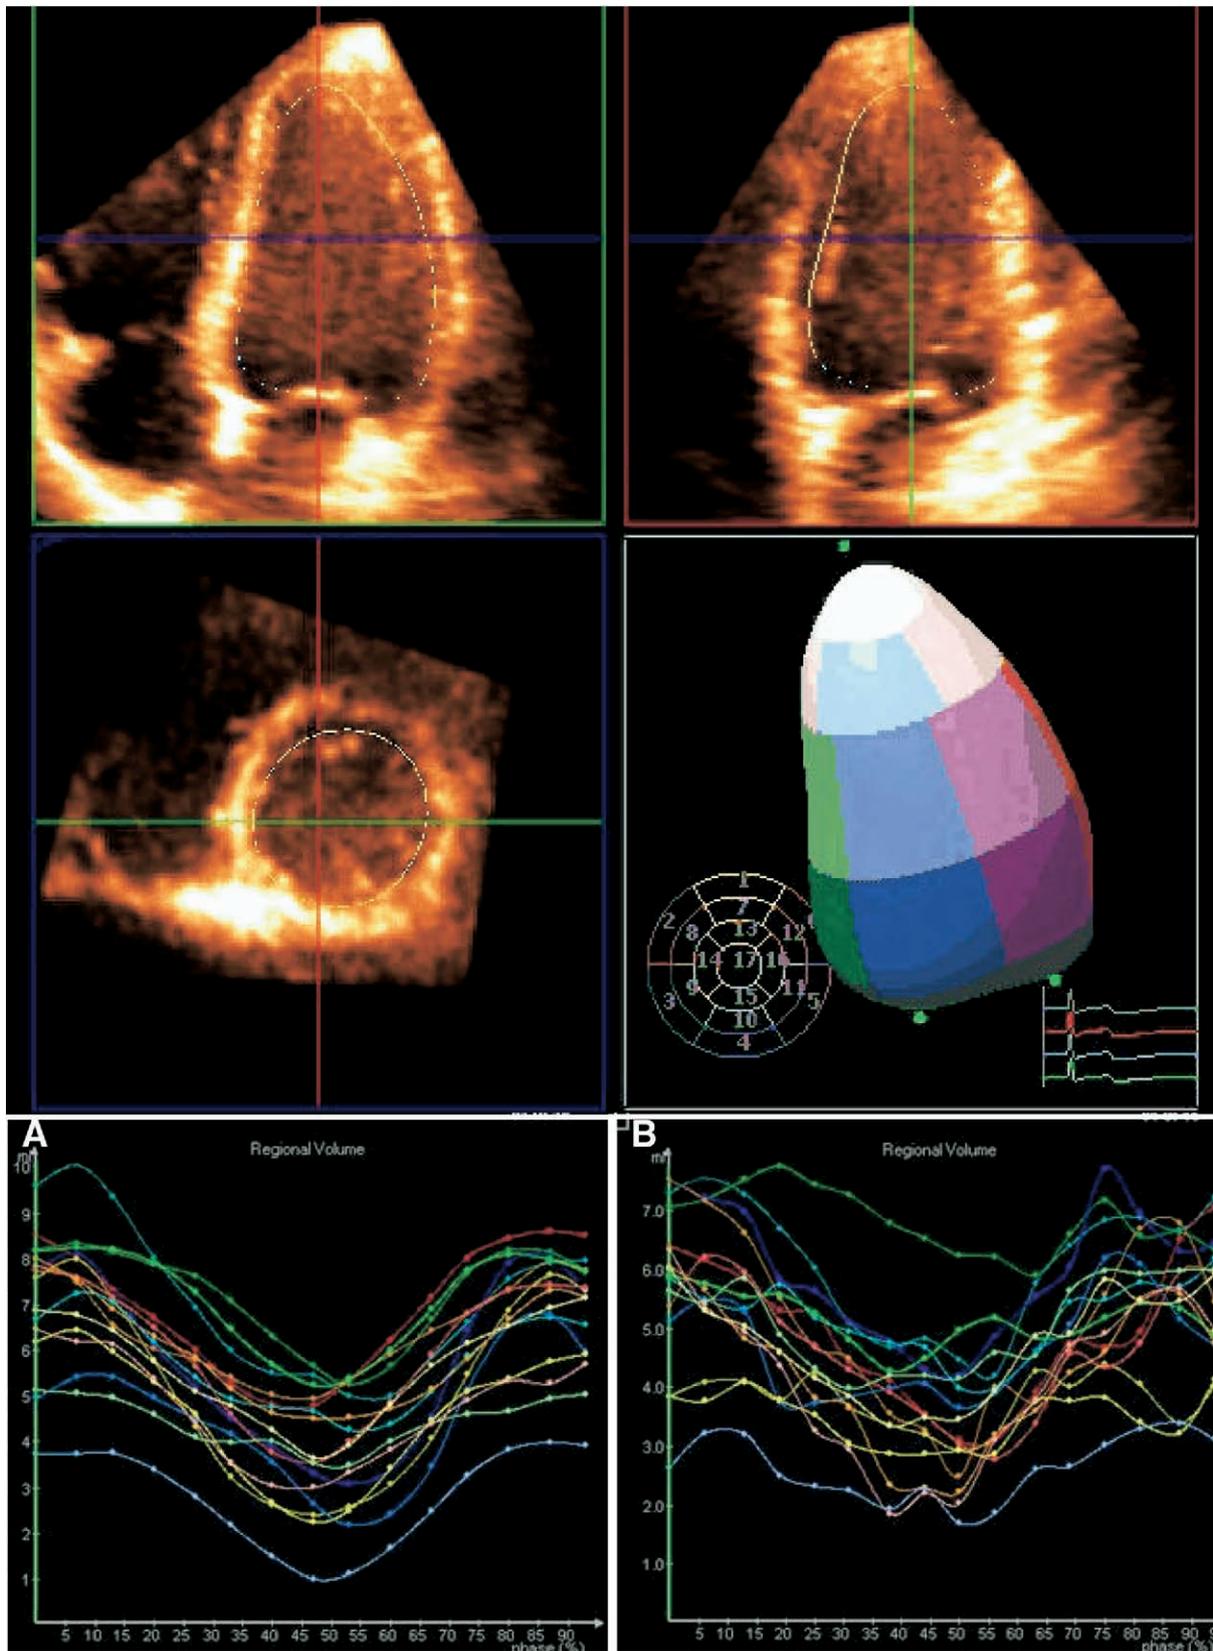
Three-dimensional echocardiographic assessment of segmental volume displacement in patient with normal synchrony (A) and with significant dyssynchrony (B).
